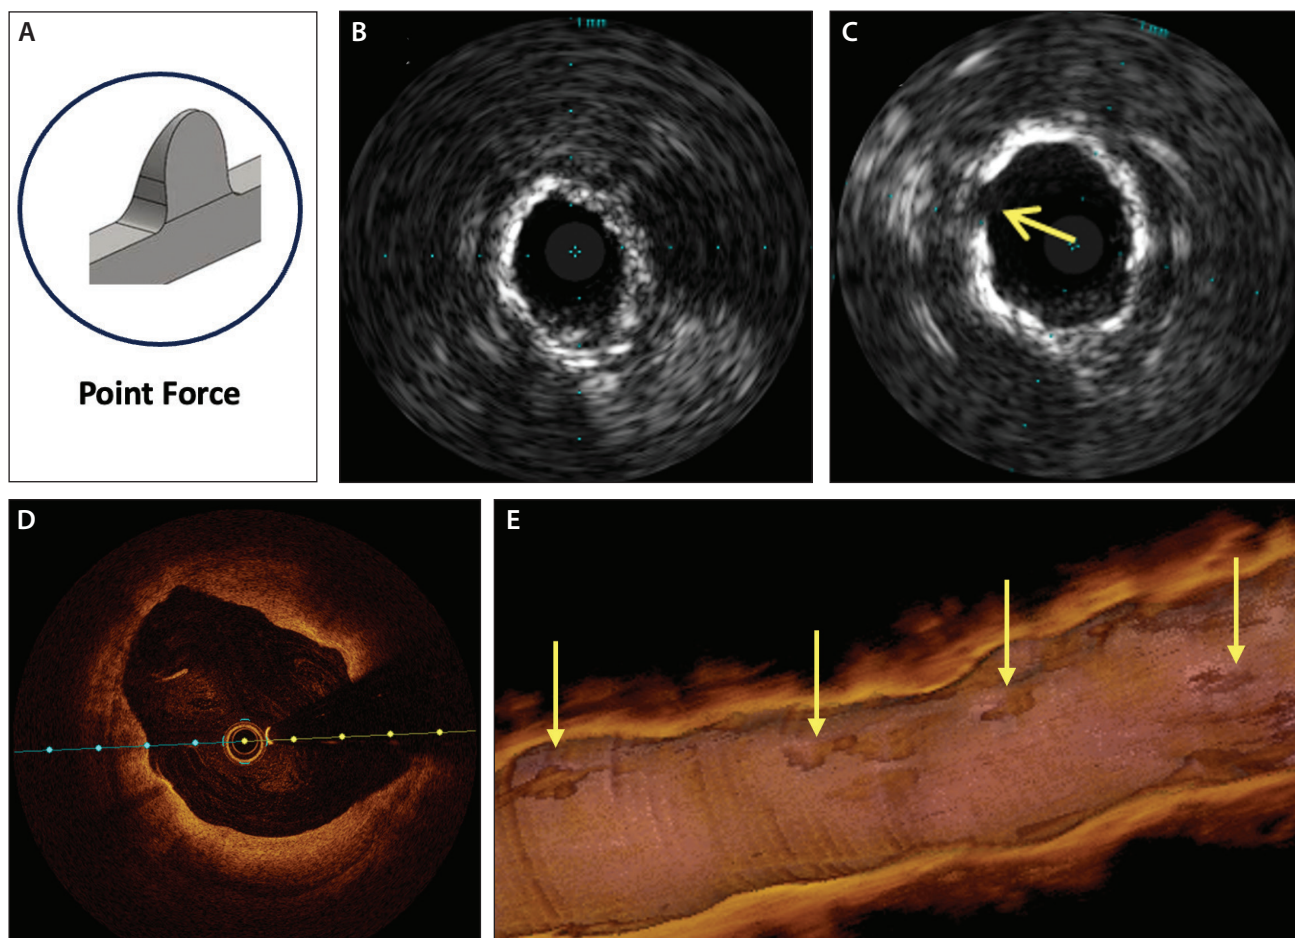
Serranator applies 1,000 times the force compared to POBA (A). Pre- (B) and post-Serranator (C) intravenous ultrasound images of the tibial artery demonstrate the effectiveness in calcification. Post-Serranator optical coherence tomography (OCT) shows the serration technology mechanism of action in the superficial femoral artery (D). Post-Serranator OCT shows serration effect within tibial artery (arrows, E).
